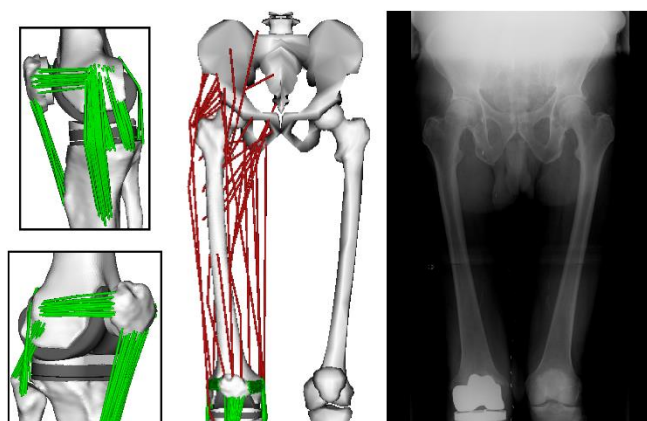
The knee model used subject-specific bone and TKR component geometry and included an extensible patellar tendon (PT) and 11 ligament bundles: anteriolateral and posteriomedial posterior cruciate ligament (aPCL, pPCL), superficial and deep medial collateral ligament (sMCL, dMCL), lateral collateral ligament (LCL), popliteofibular ligament (PFL), posteriomedial capsule (pmCAP), posterior capsule (CAP), iliotibial band (ITB), medial patellofemoral ligament (MPFL), and lateral patellofemoral ligament (LPFL). The knee model was integrated into a generic lower extremity model which included 44 muscle-tendon units acting about the hip, knee and ankle. The coronal plane TKR component alignment in the nominal model was set to match the limb alignment measured for the subject in a standing radiograph.
